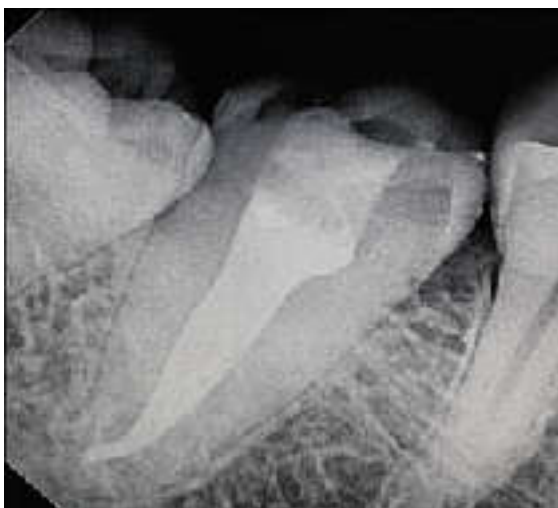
Radiograph showing obturation #47.
